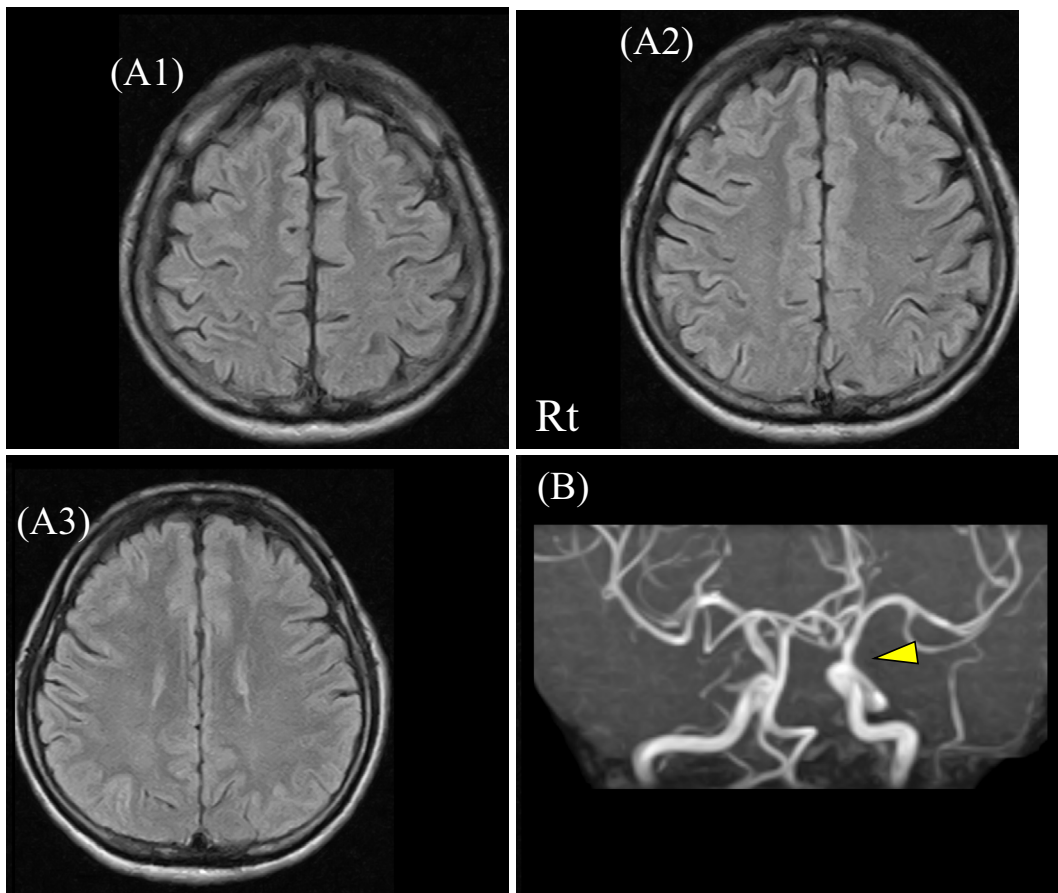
MRI of the brain (axial FLAIR and MRA) performed two months after the initial headache. (A1-3) No hyperintensity is seen on FLAIR images. (B) MRA depicts slight stenosis in the left intradural ICA distal to the dural ring (arrowhead). MRI: magnetic resonance imaging, FLAIR: fluid-attenuated inversion recovery, MRA: magnetic resonance angiography, ICA: internal carotid artery
